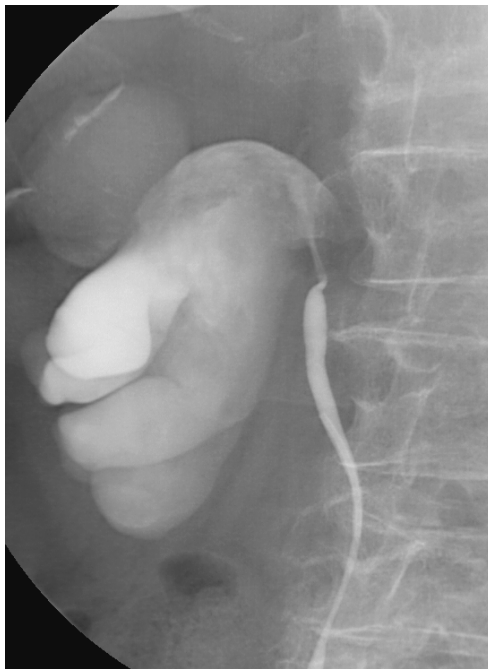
Retrograde ureteropyelogram (RUP) showing tight pelvi-ureteric junction obstruction and hydronephrosis of the right kidney. The filling defects seen on CT within the collecting system were not identified at RUP.
